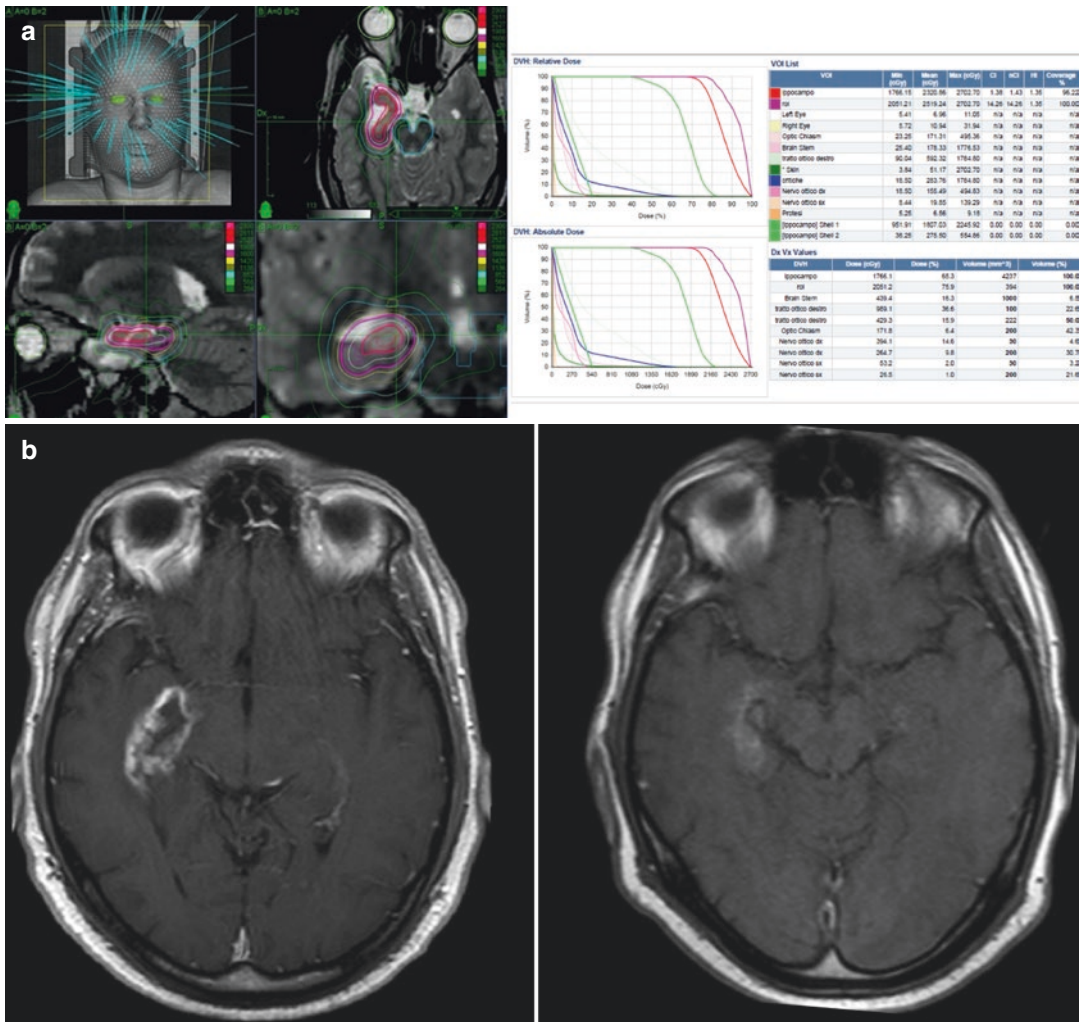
(a) CyberKnife radiosurgery treatment plan for mesial temporal sclerosis. (b) (Left) MRI showing the development of a radionecrosis in the target area at
